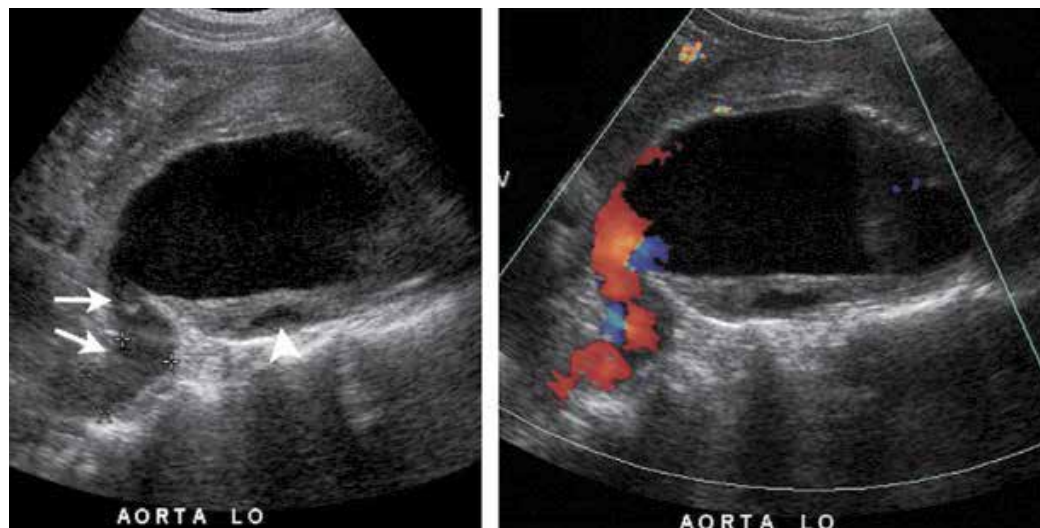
Ultrasonic appearance of rupture. Left: Longitudinal B-mode image demonstrating a “tubular hypoechoic structure (arrows), which is continuous with the lumen of the aneurysm sac”. The hypoechoic area in the thrombus (arrowhead) is a sign of aortic wall rupture. Right: Corresponding duplex image demonstrating an active bleeding. *In Bhatt et al. (2007), used with permission.*
